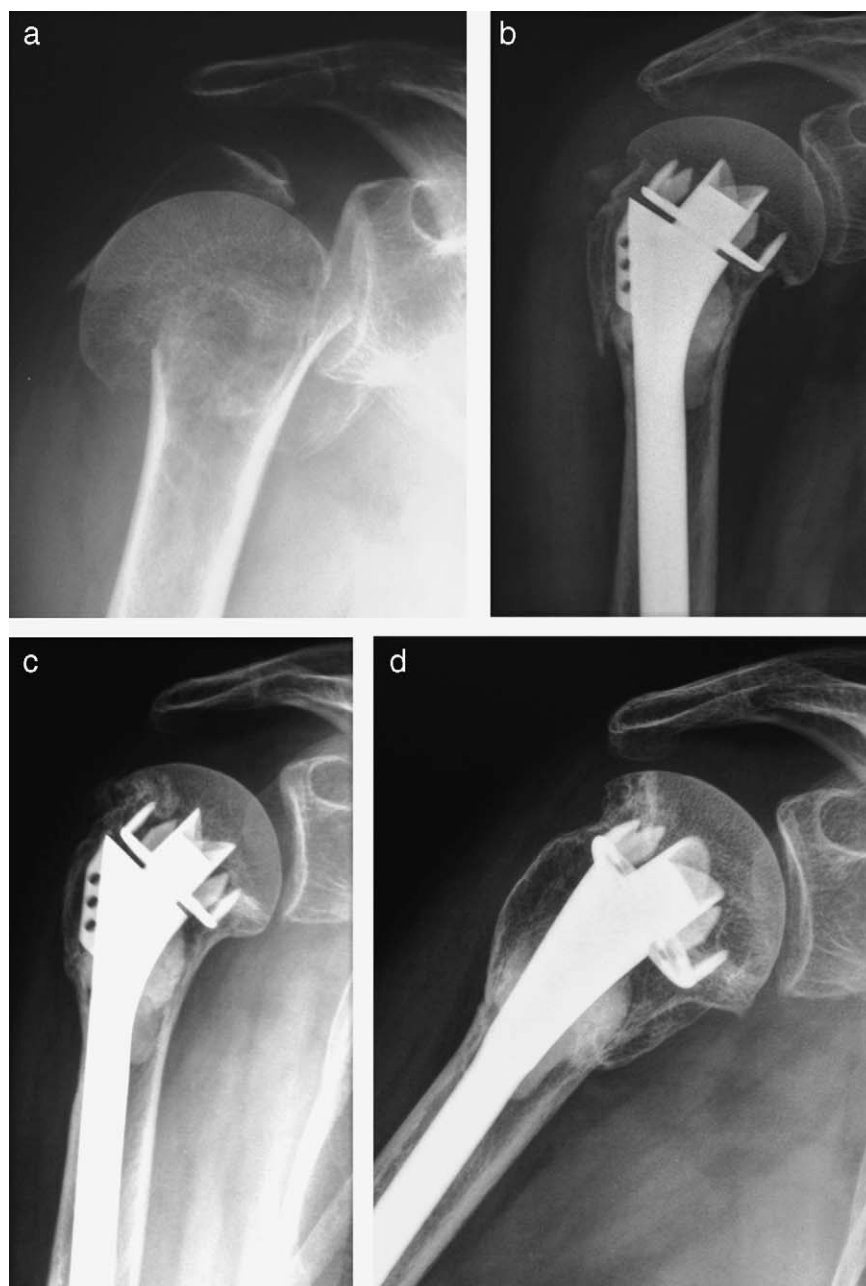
a: four-part fracture; case No. 6 in Table 1; b: postoperative results at 3 months; the absence of a medial metaphyseal head extension is observed and cement in the metaphysis to block the stem; c and d: radiographic results at 34 months on AP view with internal rotation.
